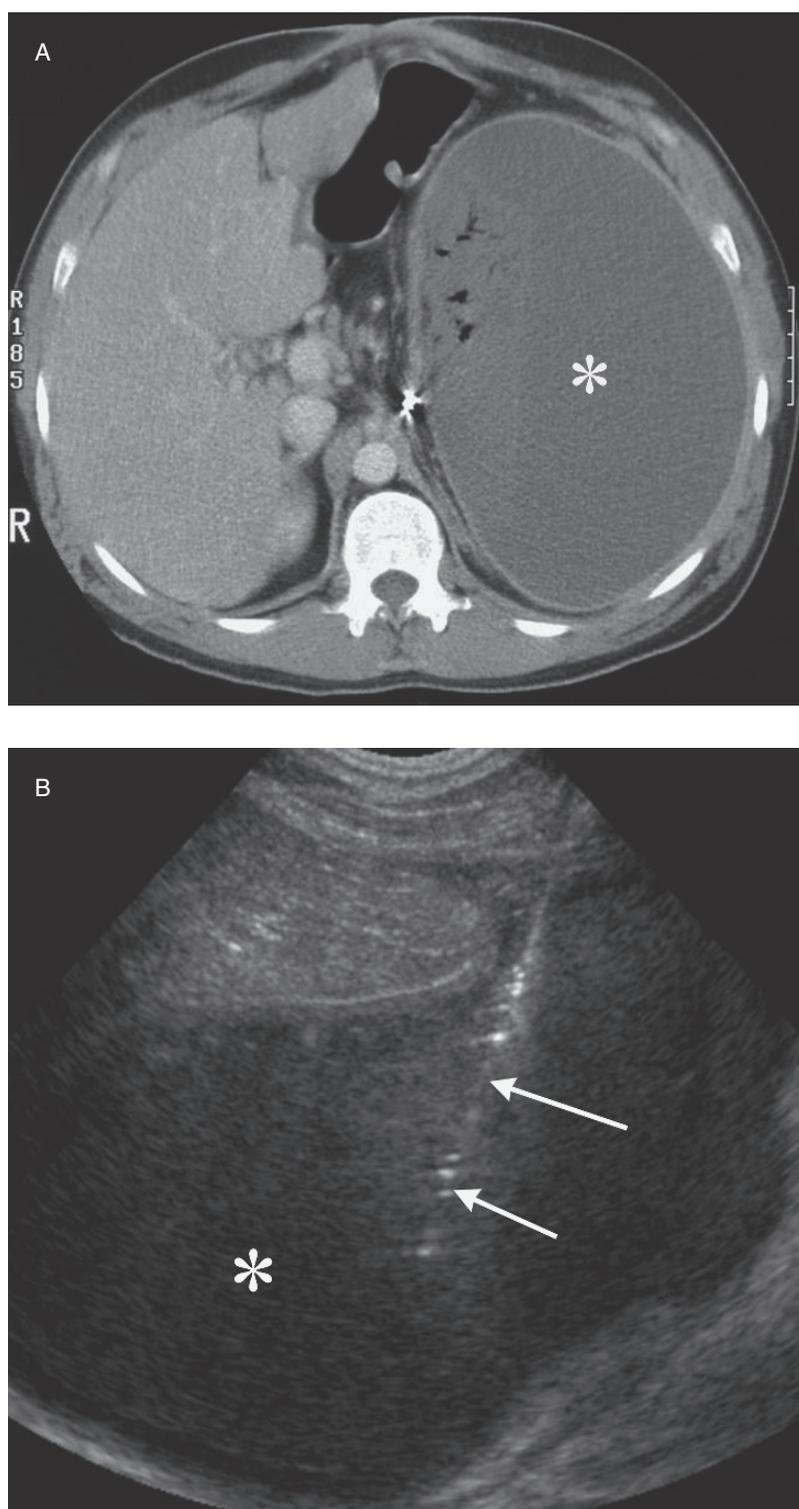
Splenic abscess. (A) CT shows a large abscess (*) in the splenic bed after splenectomy. (B) Needle (arrows) placement into the abscess (*) with ultrasound guidance.
